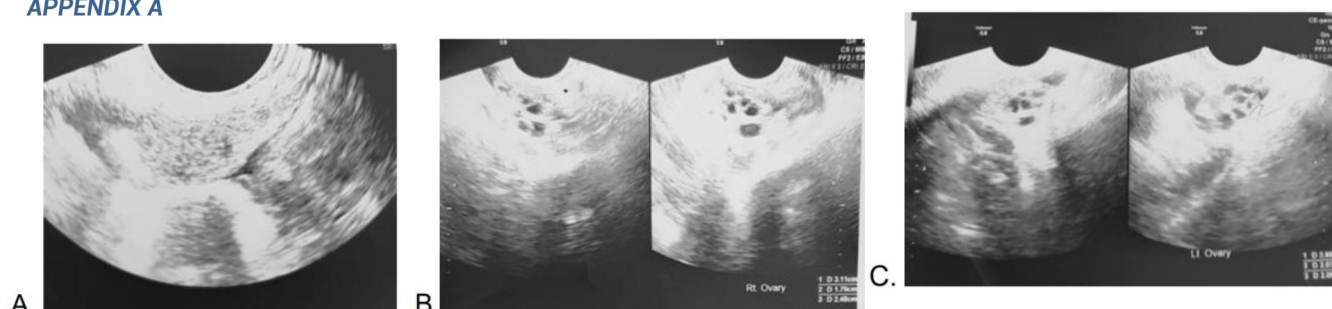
Transrectal ultrasound images. A: Uterus. B: Right ovary. C: Left ovary.
